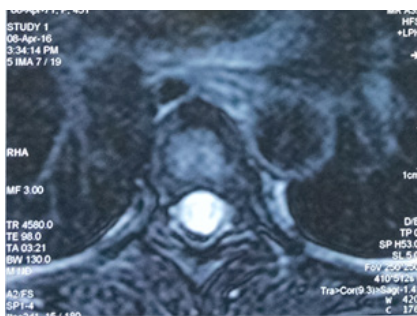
MRI spine transverse section T2W image showing hyper intensity of cord at D6 level
